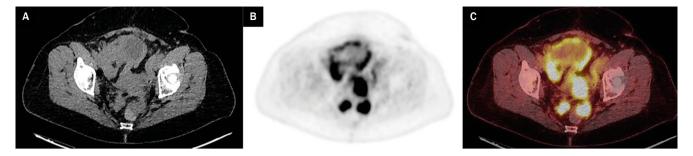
Axial CT (A), [18F]FDG PET (B) and fused [18F]FDG PET/CT (C) of the pelvis show multiple avid tumour deposits close to the vaginal stump from a previous total abdominal hysterectomy and bilateral salpingo-oophorectomy
